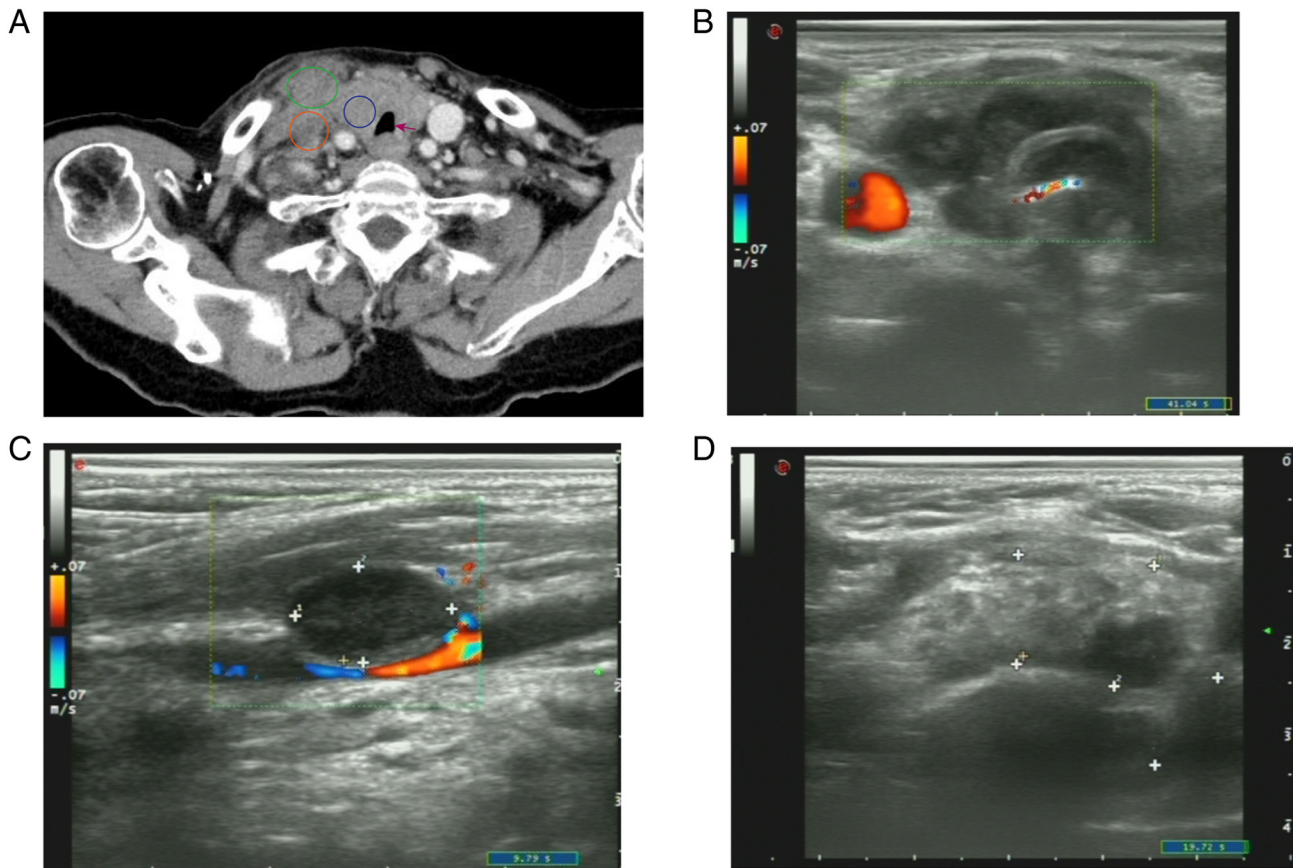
Preoperative imaging. (A) Axial CT image demonstrates diffuse enlargement of the residual thyroid tissue (blue circle) with marked compression and rightward displacement of the trachea (red arrow). An intraluminal tumor thrombus is visible in the right internal jugular vein (orange circle). Enlarged metastatic lymph nodes are present in the cervical regions (green circles). (B) Color Doppler ultrasonography of the thyroid isthmus revealing a 12-mm thick irregular hyperechoic area (rectangle); normal thyroid parenchyma is not observed. (C) Ultrasonography of the right lobe showing an irregular hypoechoic lesion (white plus sign) exhibiting ill-defined borders with the trachea. (D) Ultrasonography of the right neck demonstrating multiple hypoechoic masses (white plus signs) representing lymphadenopathy, the largest measuring 13x8 mm.
